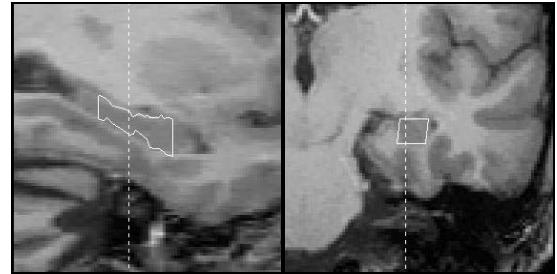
Sagittal (left) and coronal (right) views of T1-weighted MRI with cross sections of initial models overlaid.
